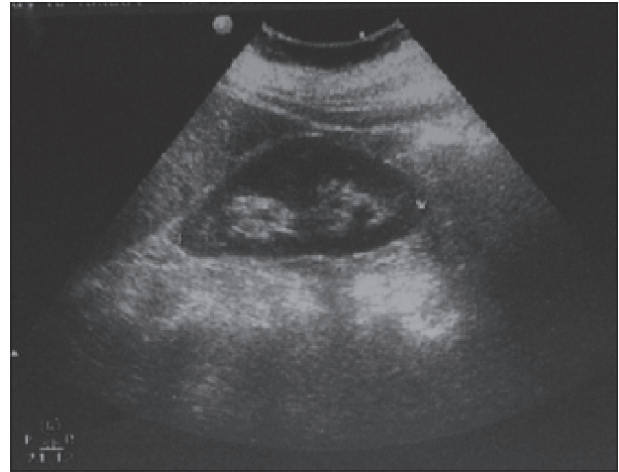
Ultrasonography abdomen
